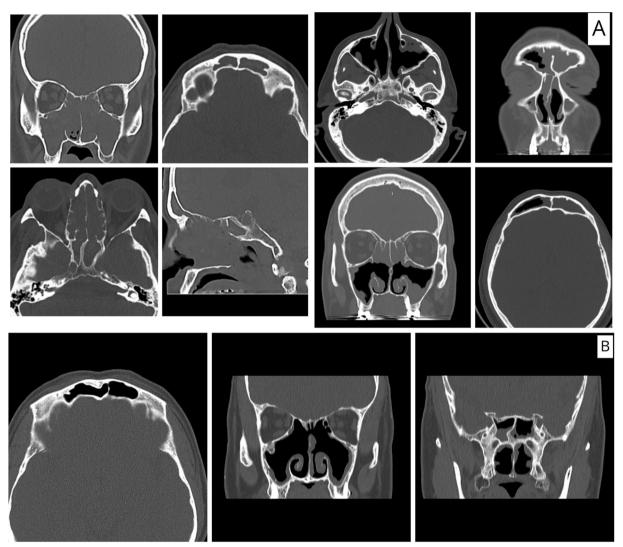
Changes in CT-PNS before and after dupilumab In the (A) collection, the figure showed complete and partial opacification of PNS, the LMS was above 10, however, in the (B) collection, the effect of dupilumab was obvious; the figure showed absence or even mild opacification of both maxillary and both sphenoid sinuses with clear frontal, anterior ethmoid, posterior ethmoid with non-obstructed ostiomeatal complexes, with a score of less than 10 of 24 according to LMS. Recruitment period (0-12 months), and follow-up period (12-24 months).
